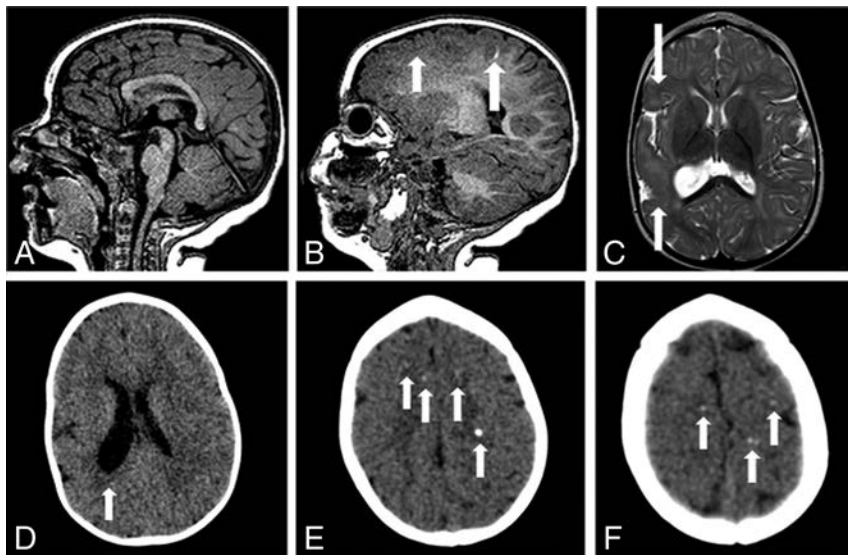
MR imaging and CT of an 8-month-old girl without microcephaly with probable congenital Zika syndrome. Sagittal T1-weighted image shows a normal corpus callosum and cisterna magna (A) and a small hyperintense focus of dystrophic calcification in the junction between the cortical and subcortical white matter (long white arrow) and left frontal polymicrogyria (short white arrow) (B). Axial T2-weighted image (C) shows right polymicrogyria (white arrows) and mildly decreased right hemisphere volume. CT scans show asymmetric hemispheres, with an enlarged right lateral ventricle (white arrow) (D) and small punctate foci, representing calcifications, at the cortico-subcortical white matter junction bilaterally in the frontal lobes (white arrows) (E and F).
